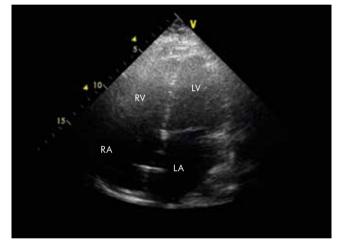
Transthoracic echocardiography. Apical four-chamber view. Enlargement of both atria. LV – left ventricle, RV – right ventricle, LA – left atrium, RA – right atrium; right atrial pacemaker electrode
